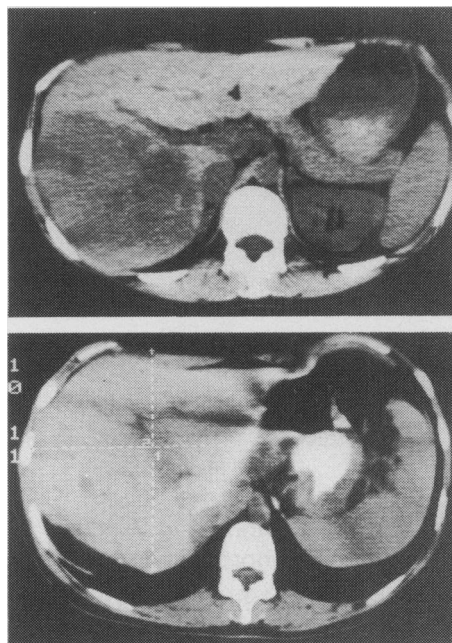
CT scan showing 10 cm tumour right lobe of liver (above) and regenerated liver (below).
